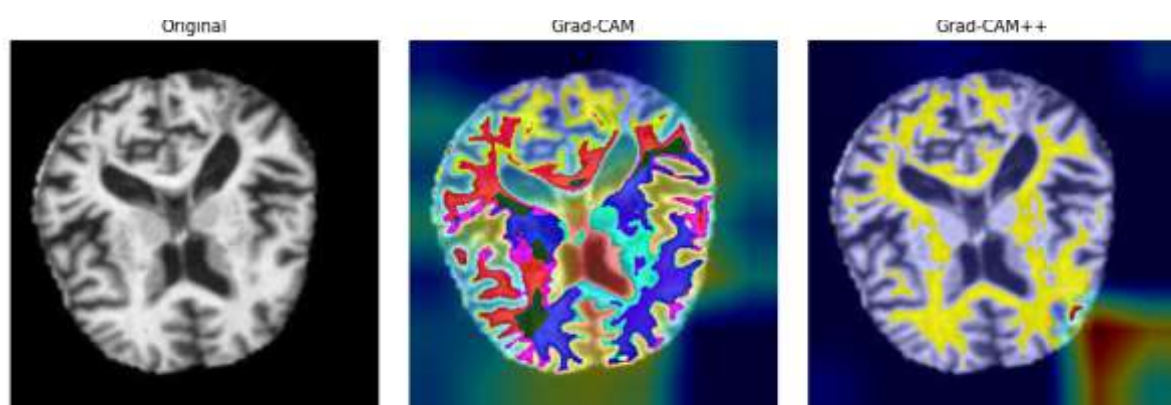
Grad-CAM and Grad-CAM++ visualization for a representative Alzheimer's MRI slice using ResNet50.
